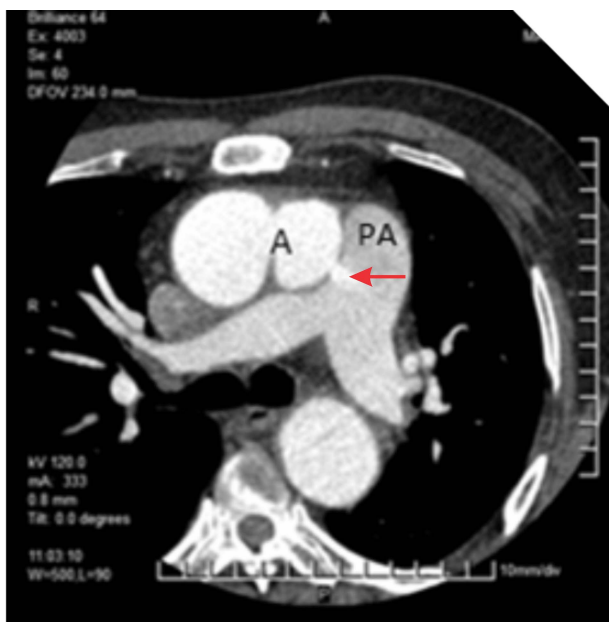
CT scan displaying the contrast axial view of the aneurysm with connection to the main pulmonary artery; the solid arrow points to the connection and depicts the flow from the aneurysm to the pulmonary artery (A, aneurysm; PA, pulmonary artery).
